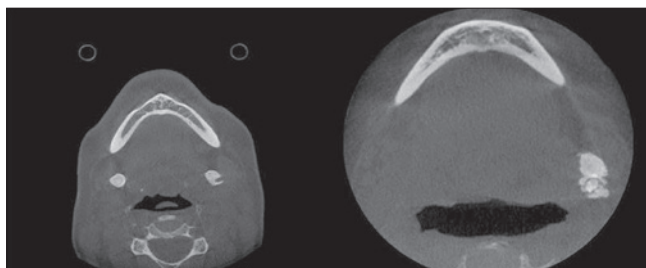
CBCT images of a patient with bilateral sub-mandibular stones (left), and a patient with a single giant left sub-mandibular stone (right).
